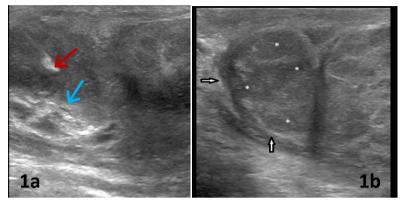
Enlarged epididymis (blue arrow) with ultrasound guided needle within (red arrow); 1b. Enlarged epididymis (arrow) with hetergenous echotexture (*).
